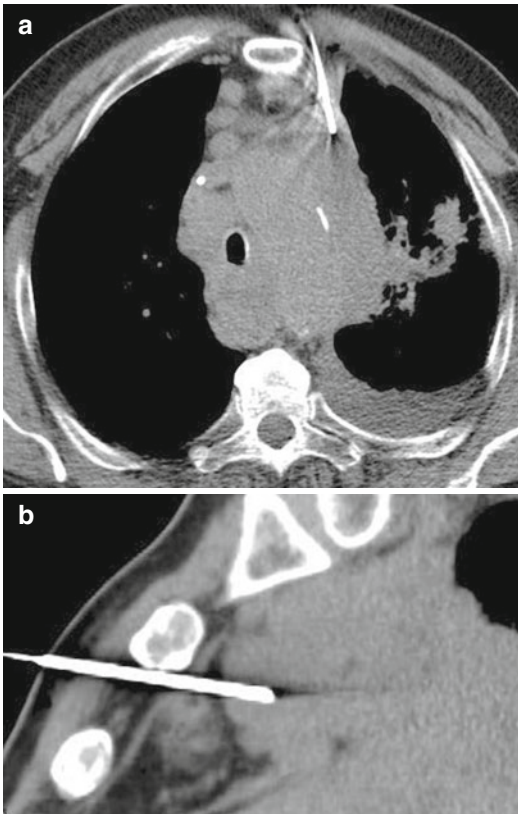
Anterior parasternal approach to a mass located in the upper anterior mediastinal compartment. Biopsy revealed lymphoma. (a) The sagittal reformation shows the needle path to be outside any critical structures (b). Biopsy revealed metastatic tumor tissue from a neuroendocrine carcinoma of unknown origin
